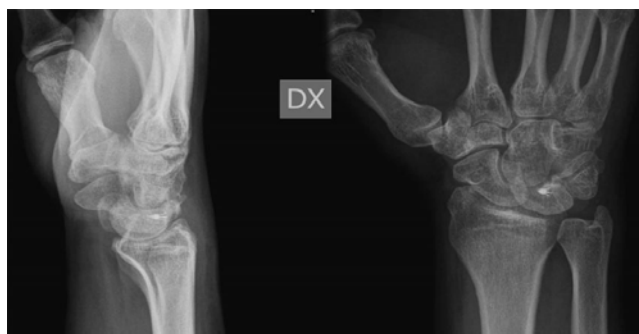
AP and LL X-rays, 6 week after surgery, following removal of the K-wires and the plaster cast.
